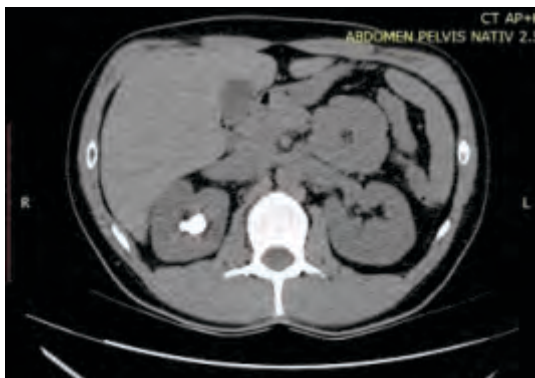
CT scan image of large pelvic stone
